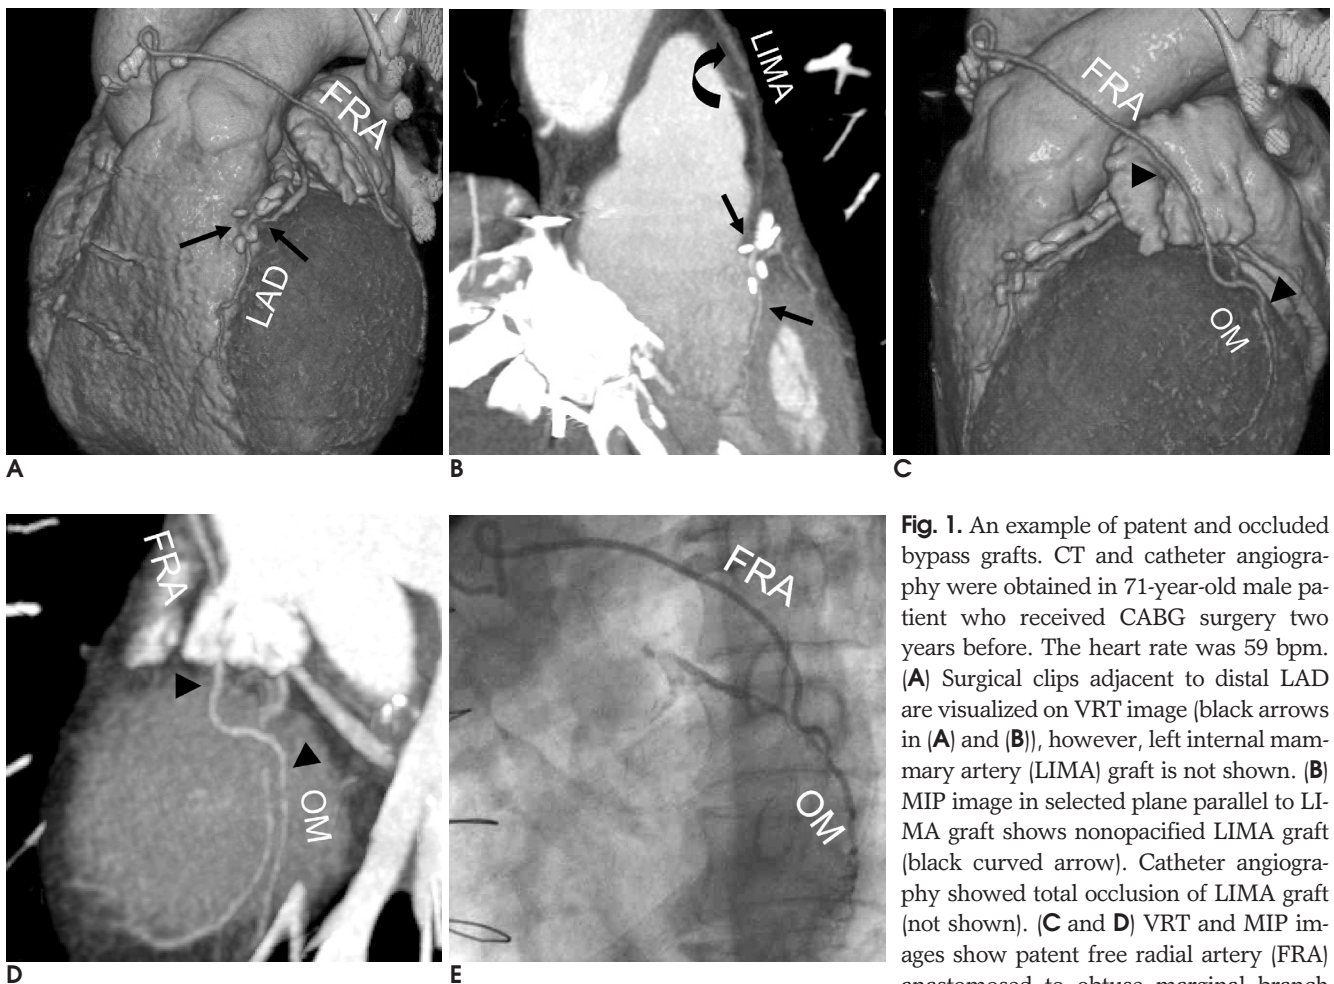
An example of patent and occluded bypass grafts. CT and catheter angiography were obtained in 71-year-old male patient who received CABG surgery two years before. The heart rate was 59 bpm. (A) Surgical clips adjacent to distal LAD are visualized on VRT image (black arrows in (A) and (B)), however, left internal mammary artery (LIMA) graft is not shown. (B) MIP image in selected plane parallel to LIMA graft shows nonopacified LIMA graft (black curved arrow). Catheter angiography showed total occlusion of LIMA graft (not shown). (C and D) VRT and MIP images show patent free radial artery (FRA) anastomosed to obtuse marginal branch (OM) (black arrowheads) (E). CAG shows patent graft and anastomosed vessel.
